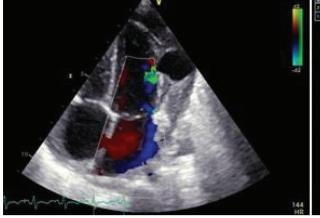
Apical 4chamber view of Echocardiogram showing the outpouching from the LV free wall with a narrow neck and color flow into the sac
